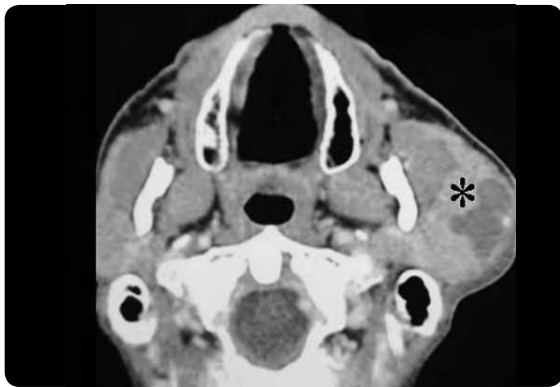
Preoperative axial computed tomography image showing a well-circumscribed mass in left parotid gland (asterisk).
